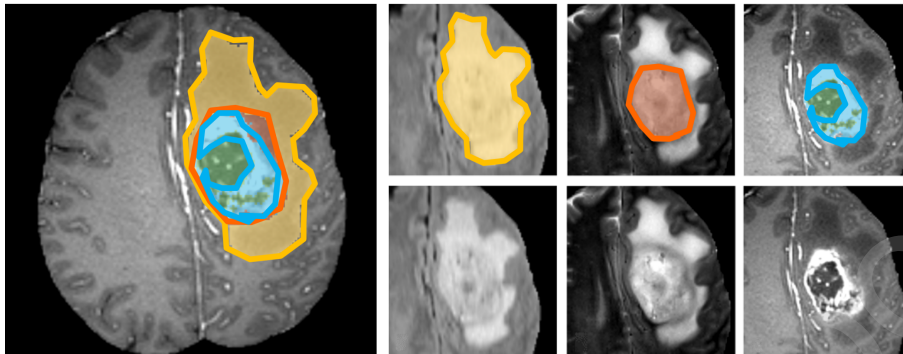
Semantic annotations available in the BRATS data set: Labels (shown in the left) summarize three semantic regions: whole tumor as visible from hyper-intense areas in T2w and FLAIR images (left column, yellow), the tumor core visible heterogenous signals in T2w MRI (central column, red), and the active tumor visible from intensity enhancements in post-Gd T1w scans (right column, blue).
